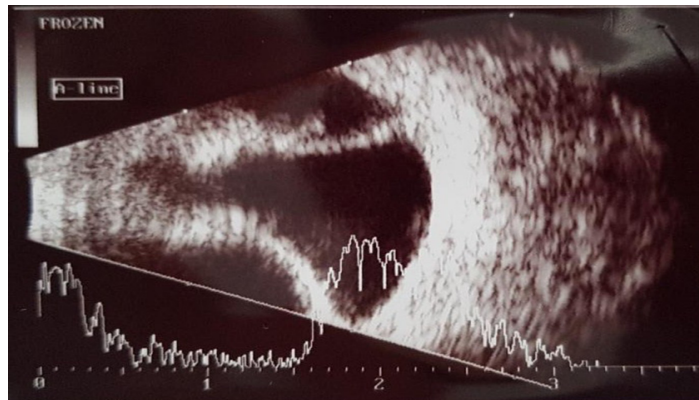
B-scan ultrasound findings after sclero-trabeculectomy for the right eye of a patient with primary open-angle glaucoma refractory to topical medications, a large serous choroidal detachment can be observed.
